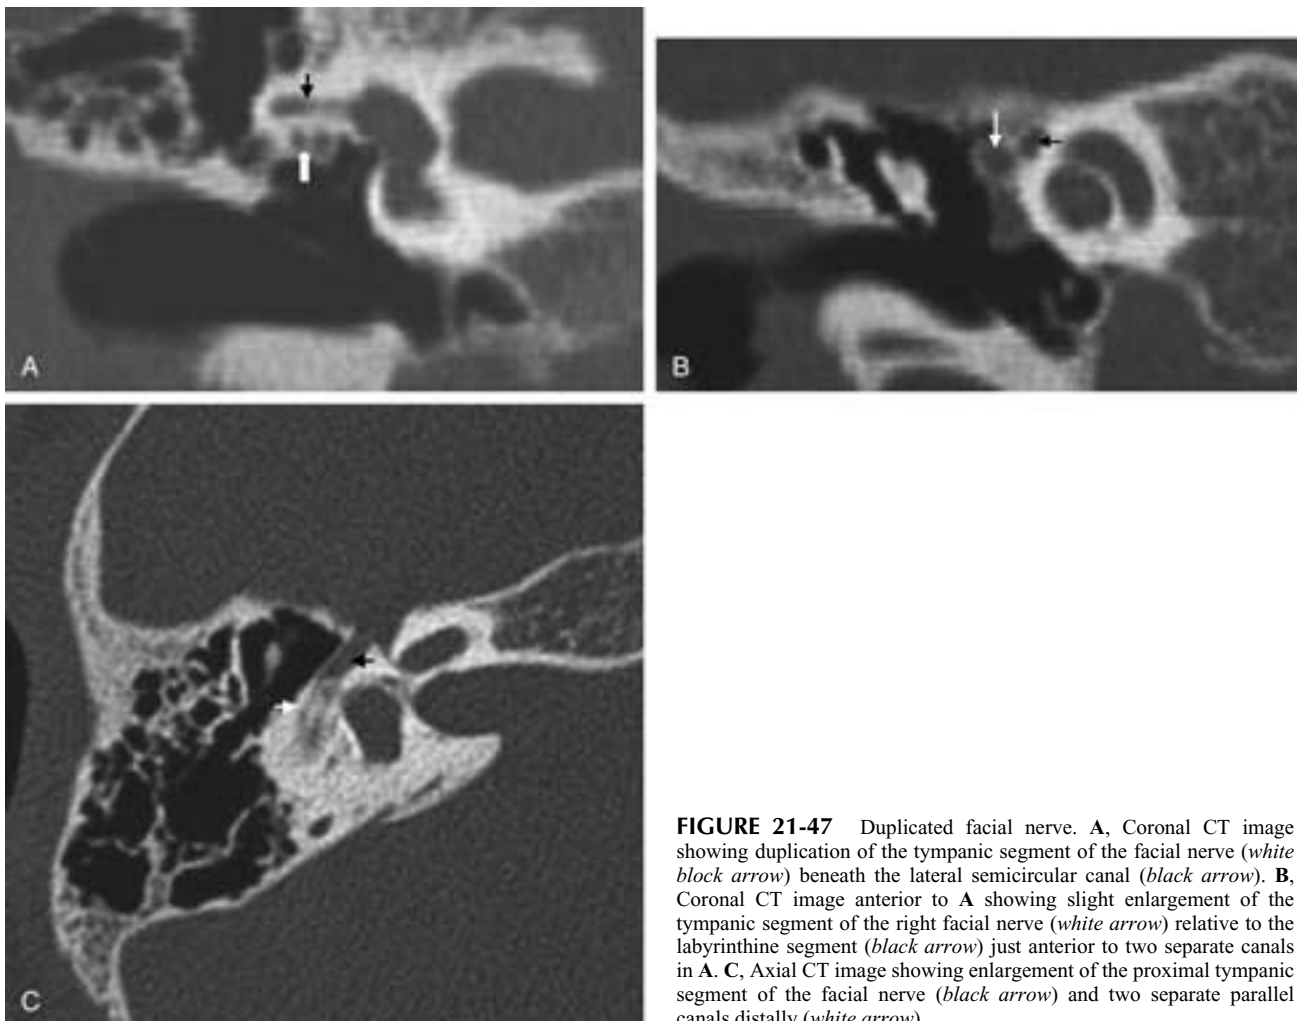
Duplicated facial nerve. A, Coronal CT image showing duplication of the tympanic segment of the facial nerve (*white block arrow*) beneath the lateral semicircular canal (*black arrow*). B, Coronal CT image anterior to A showing slight enlargement of the tympanic segment of the right facial nerve (*white arrow*) relative to the labyrinthine segment (*black arrow*) just anterior to two separate canals in A. C, Axial CT image showing enlargement of the proximal tympanic segment of the facial nerve (*black arrow*) and two separate parallel canals distally (*white arrow*).
